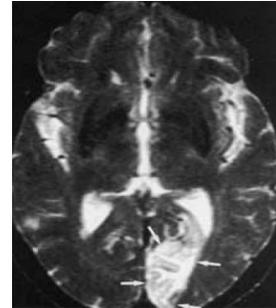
MRI brain (axial T2Wsequence) showing ischemic insult in left occipital lobe.
